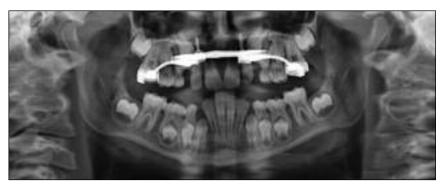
Same patient as in Figs 8 and 9. Panoramic radiograph at the end of the retention phase with the hybrid hyrax in situ.
